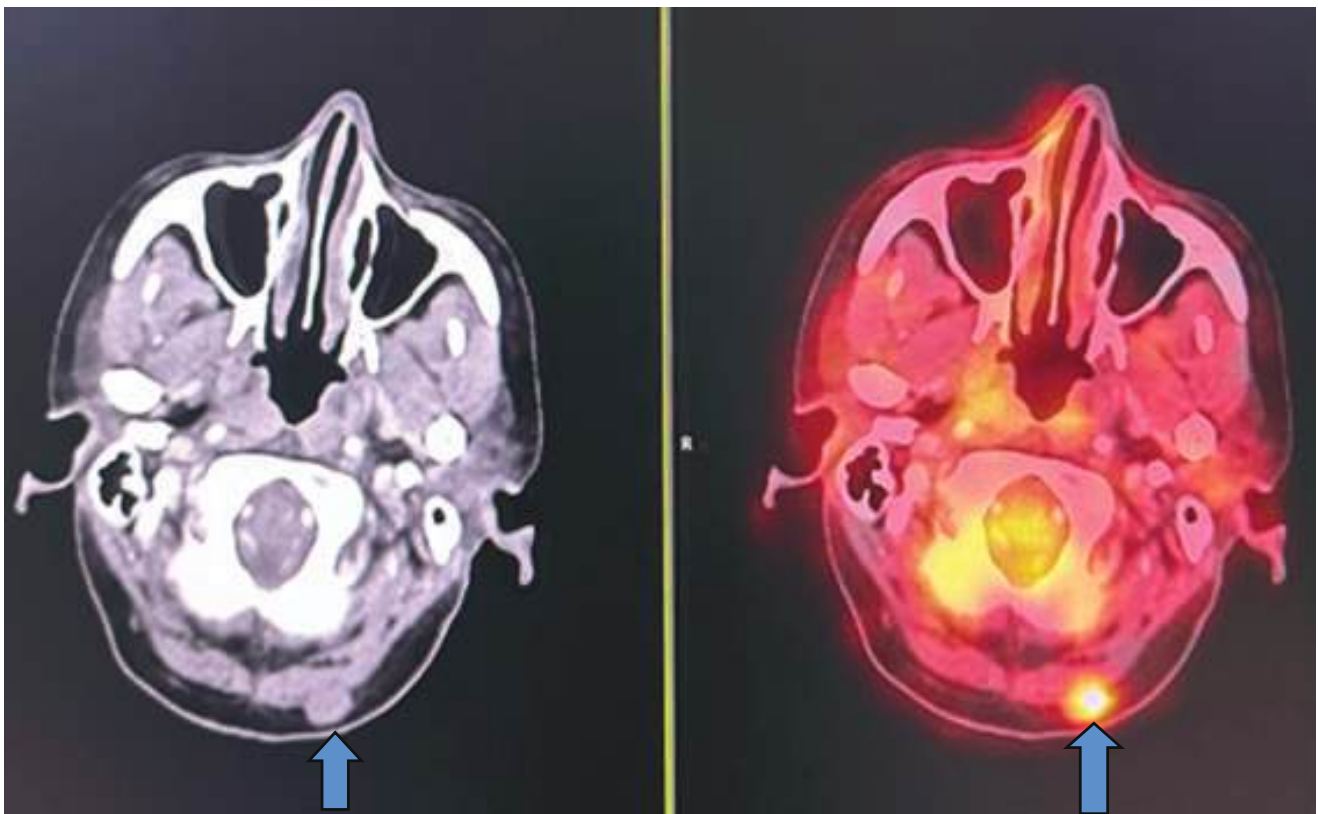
Nodal infiltration from treated primary breast cancer in a 67 year old patient treated with NACT, RT and surgery. Enlarged FDG avid (SUV:7.28) left occipital lymph node is noted (blue arrow).
